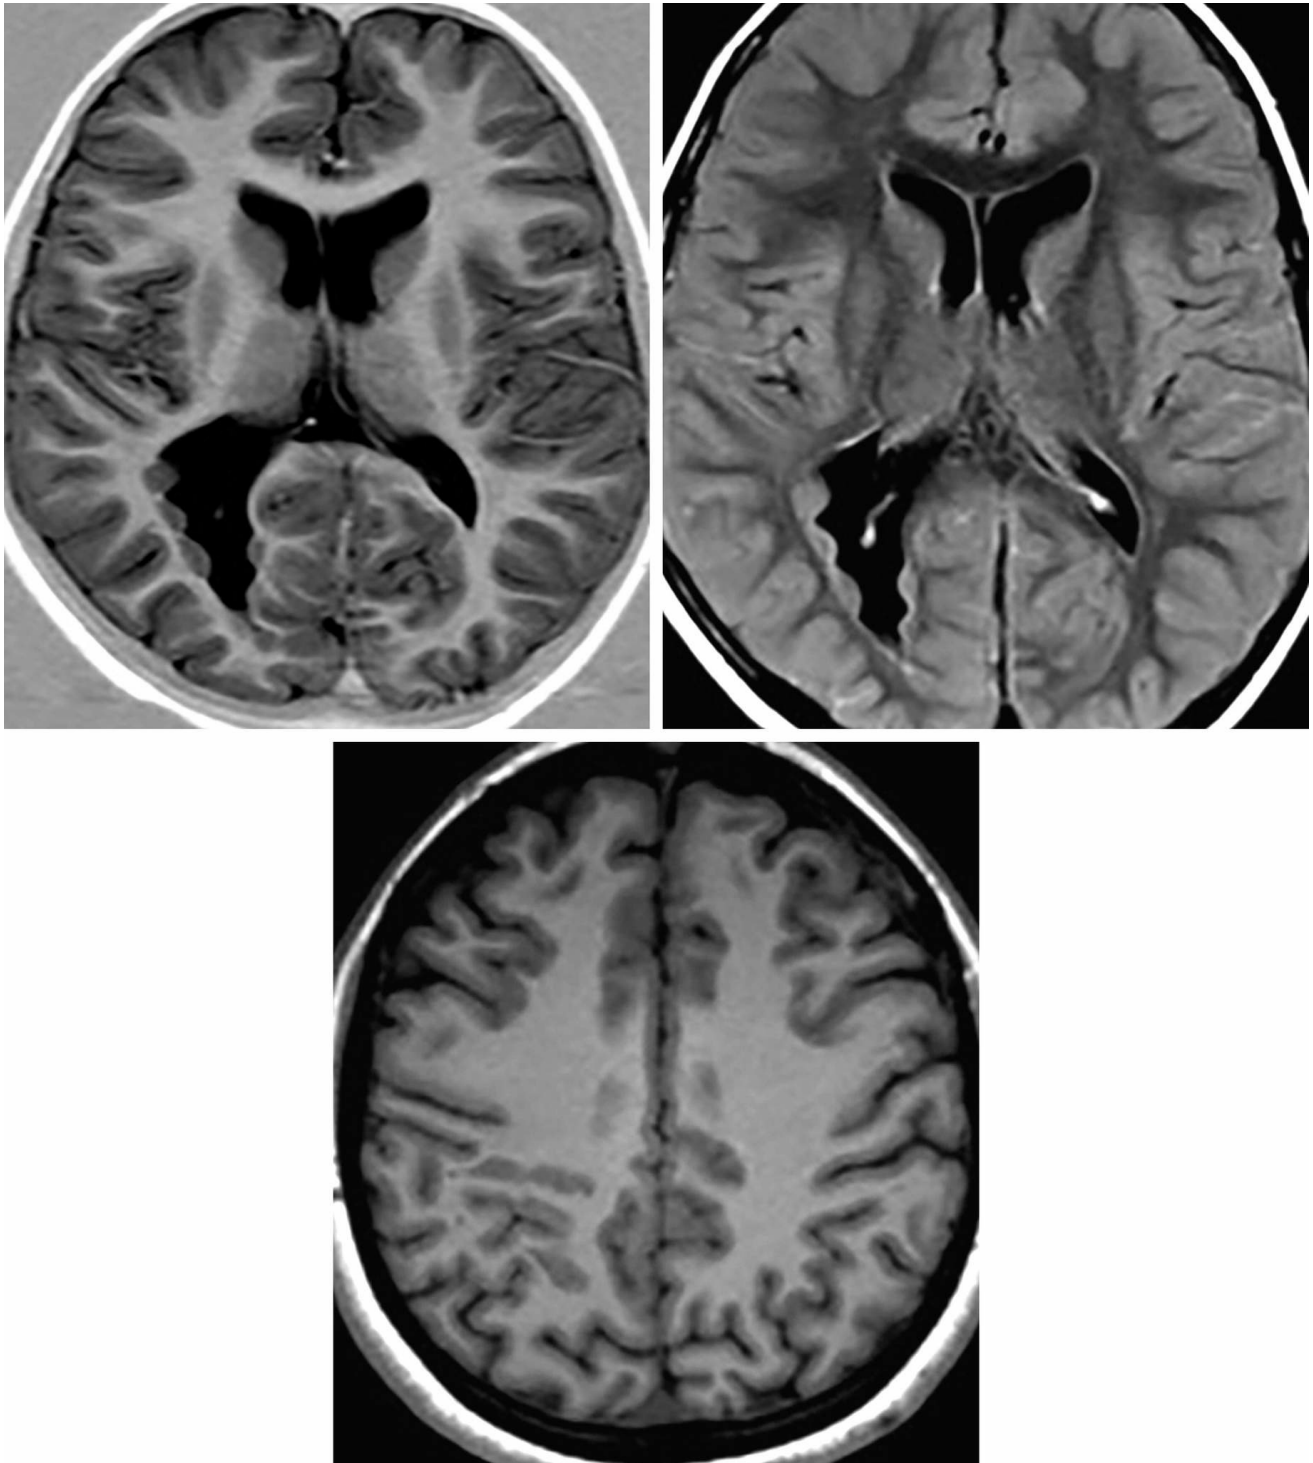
Phase-sensitive (T1-weighted) inversion recovery (top left) and FLAIR (top right) sequences demonstrate a cluster of nodules along the ependymal surface of the posterior horn of the right lateral ventricle.
